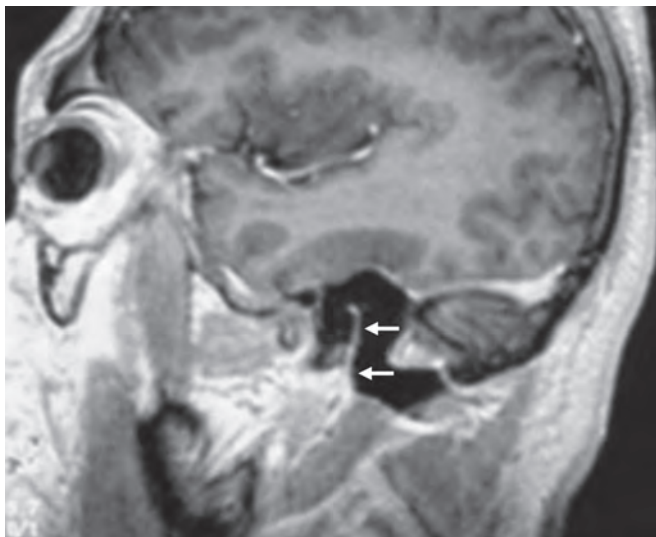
Parasagittal contrast enhanced MRI images demonstrating enhancement of mastoid segment of facial nerve (arrows) [Source: Meher R, Varshney S, Gupta P, et al. Herpes Zoster Oticus with Ménière's syndrome complex. The Internet Journal of Otorhinolaryngology. 2006;(4):2]
